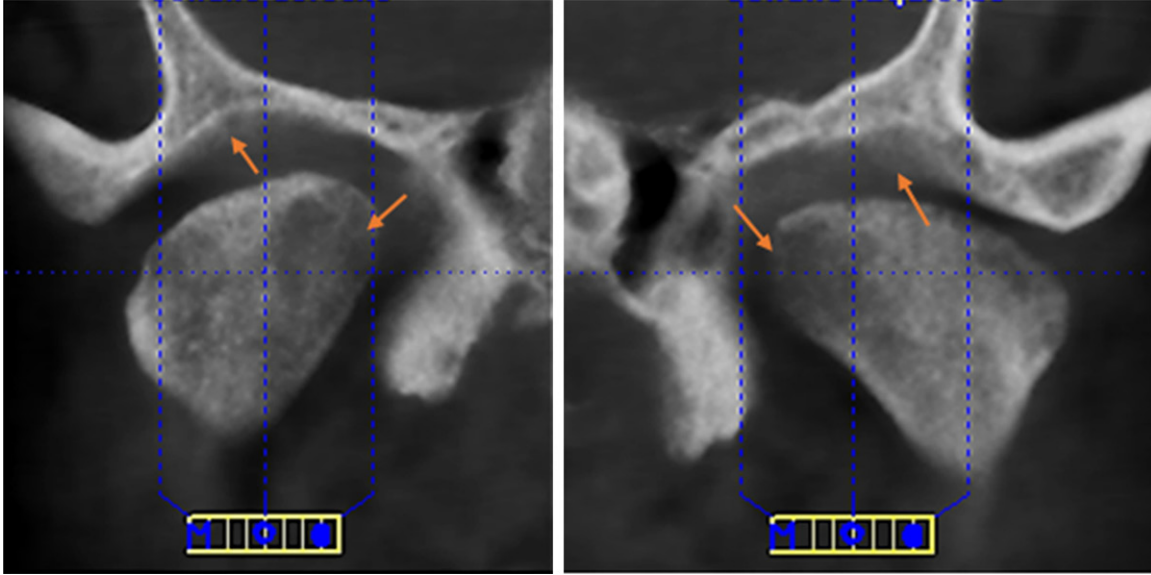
CT images of Male 60 years old. Left hand side: right condyle. Right hand side: left condyle. Observe the erosion in both temporalis.
